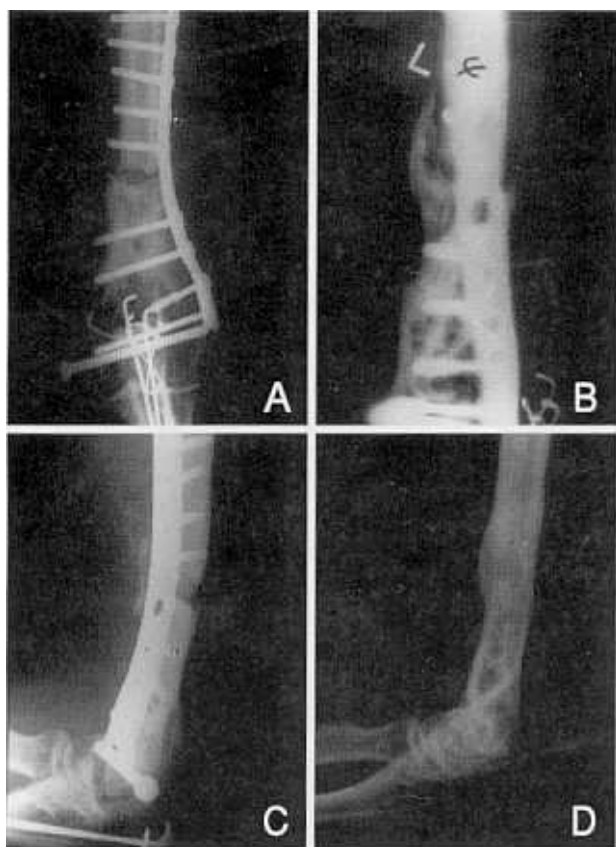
Patient 5, (A) Plain radiograph of distal humerus shows gap in the fracture site. (B) Tomography demonstrated scant callus around the fracture site. (C) Plain radiograph after endoscopic bone graft showing grafted bone on the anterior aspect of the delayed union site. (D) Two years after endoscopic bone graft, plate and screws were removed and the patient regained functional range of motion of the elbow.
